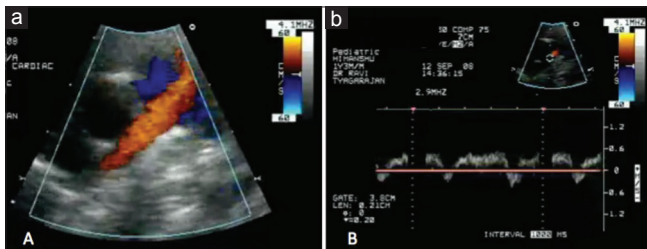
(a) Flow reversal with centripetal flow pattern on color flow mapping in the right pulmonary artery. (b) Spectral Doppler revealed a venous flow pattern in the right pulmonary artery
